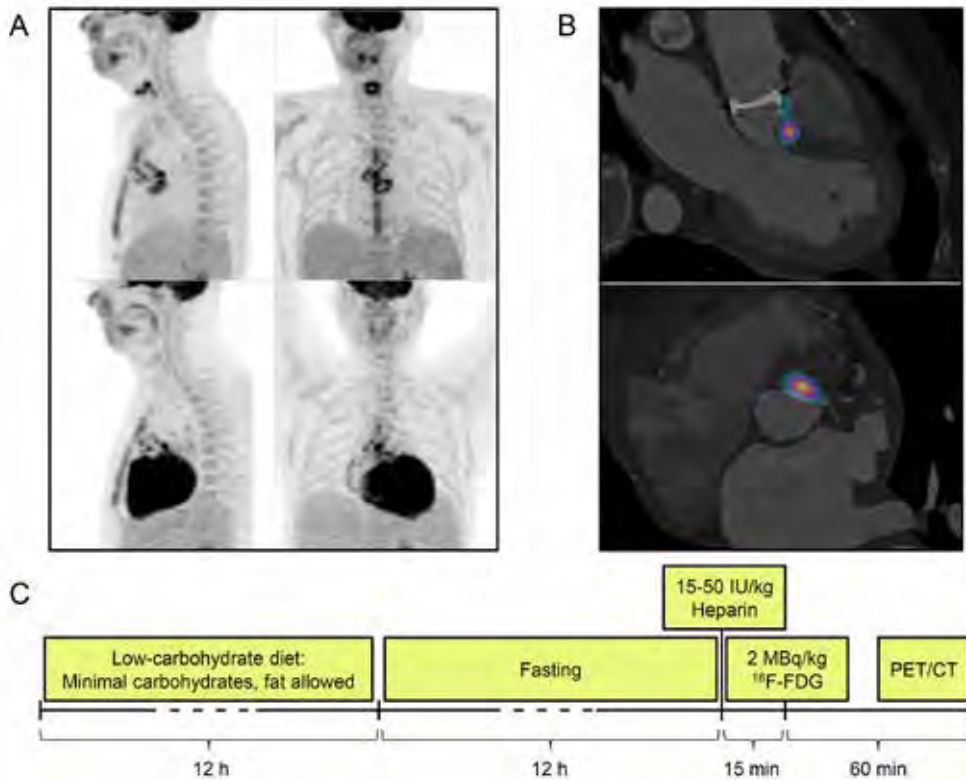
Importance of adequate suppression of myocardial ^{18}F -FDG uptake. (A) Maximum intensity projection positron emission tomography (PET) images in sagittal and coronal views of 2 scans (interval 35 days) in the same patient with endocarditis of a St. Jude mechanical prosthetic heart valve (St. Jude Medical, St. Paul, Minnesota) implanted 1 year earlier, with and without additional preparatory measures. The intense physiological uptake in the myocardium after the standard 6-h fast makes it difficult to delineate uptake caused by the infection (lower panels), whereas after the preparatory protocol, the myocardial metabolism has switched to free fatty acids and only the infectious process surrounding the prosthetic heart valve ring and ascending aorta shows uptake of ^{18}F -FDG (B), easily delineated from other structures (A, upper panels). In some cases, unsuccessful suppression can be very focal in the basal anteroseptum, directly adjacent or close to prosthetic valves and seem suspect for infection. (C) Our preparatory protocol, combining a low-carbohydrate diet, prolonged fasting and heparin pre-administration to maximize myocardial suppression (2). CT indicates computed tomography; IU, international units.
